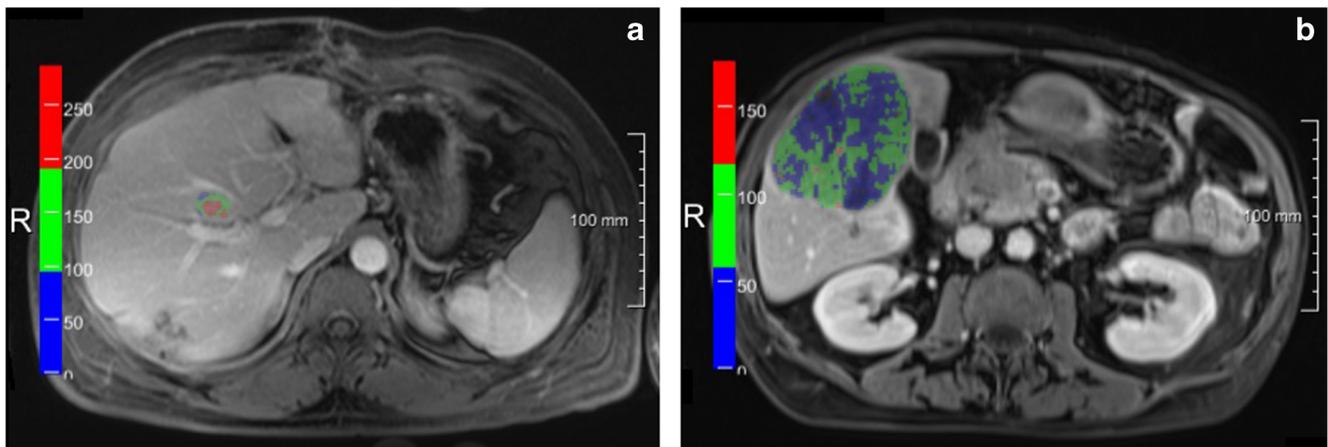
MR image (a) in a 42-year-old male patient with neuroendocrine liver metastases demonstrating low baseline tumor volume (6.3 cm³) and high baseline volumetric enhancements (AE = 162%; VE = 150%). OS was 90 months and HPFS was 42 months. MR image (b) in a 60-year-old male patient with neuroendocrine liver metastases demonstrating high
